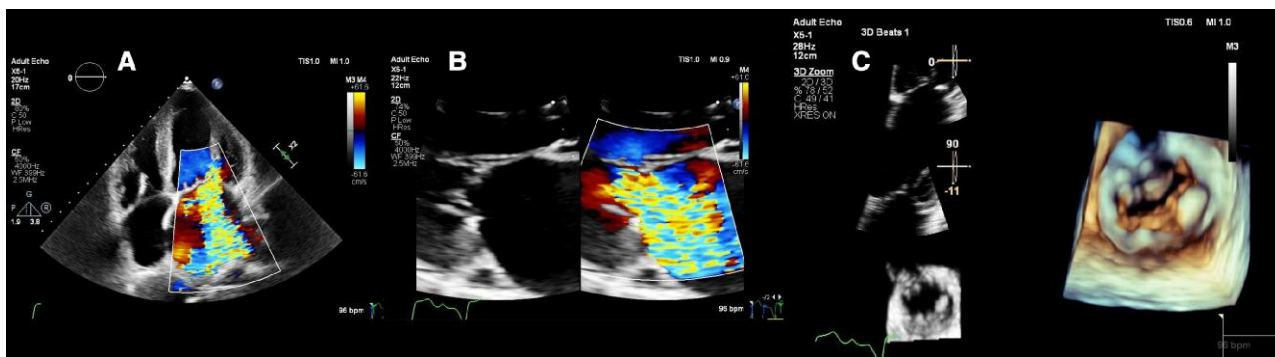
Transthoracic echocardiography 4 months following permanent pacemaker implantation with colour flow Doppler imaging in the (A) apical four-chamber and (B) parasternal long-axis view demonstrating progression to torrential mitral regurgitation. (C) Note the three-dimensional transthoracic echocardiography of the mitral valve from the left ventricular aspect demonstrating complete loss of leaflet coaptation in early systole.
